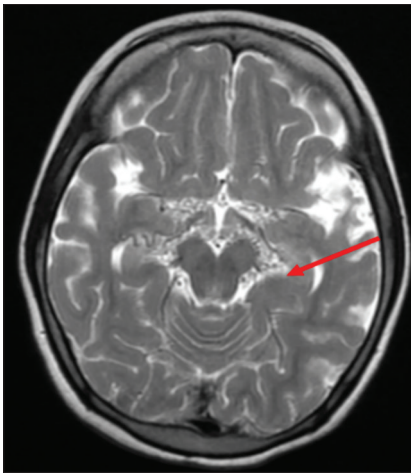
Axial T2W magnetic resonance image showing multiple flow voids in the basal cisterna (arrow) representing dilated collateral vessels
